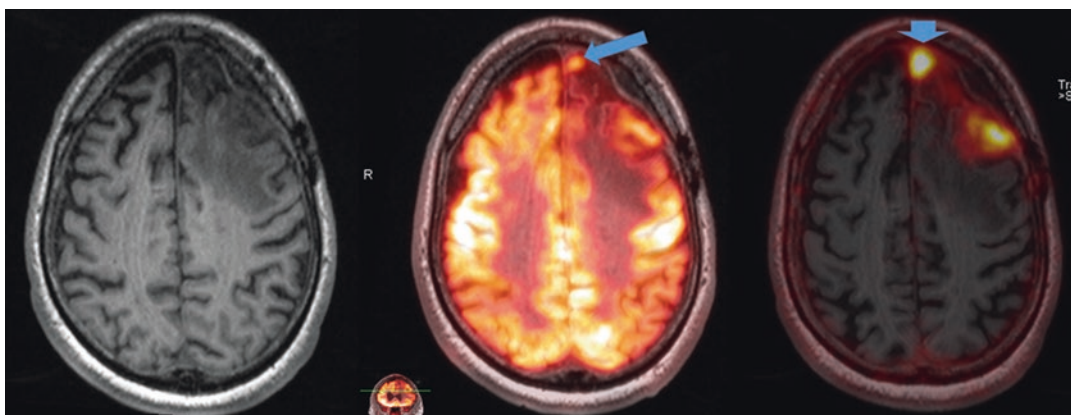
A 67-year-old man with an intracranial WHO grade III anaplastic meningioma. He underwent tumor resection followed by intensity modulated radiation therapy (IMRT) but suffered a recurrence 25 months later. He received a ¹⁸F-(FDG) and ⁶⁸Ga-DOTATATE PET/MR to evaluate for the presence of somatostatin receptor expression and guide subsequent treatment. (left) (MP-RAGE MRI section through tumor in the left frontal lobe). (middle) (Corresponding section from a ¹⁸F-(FDG) PET/MR
